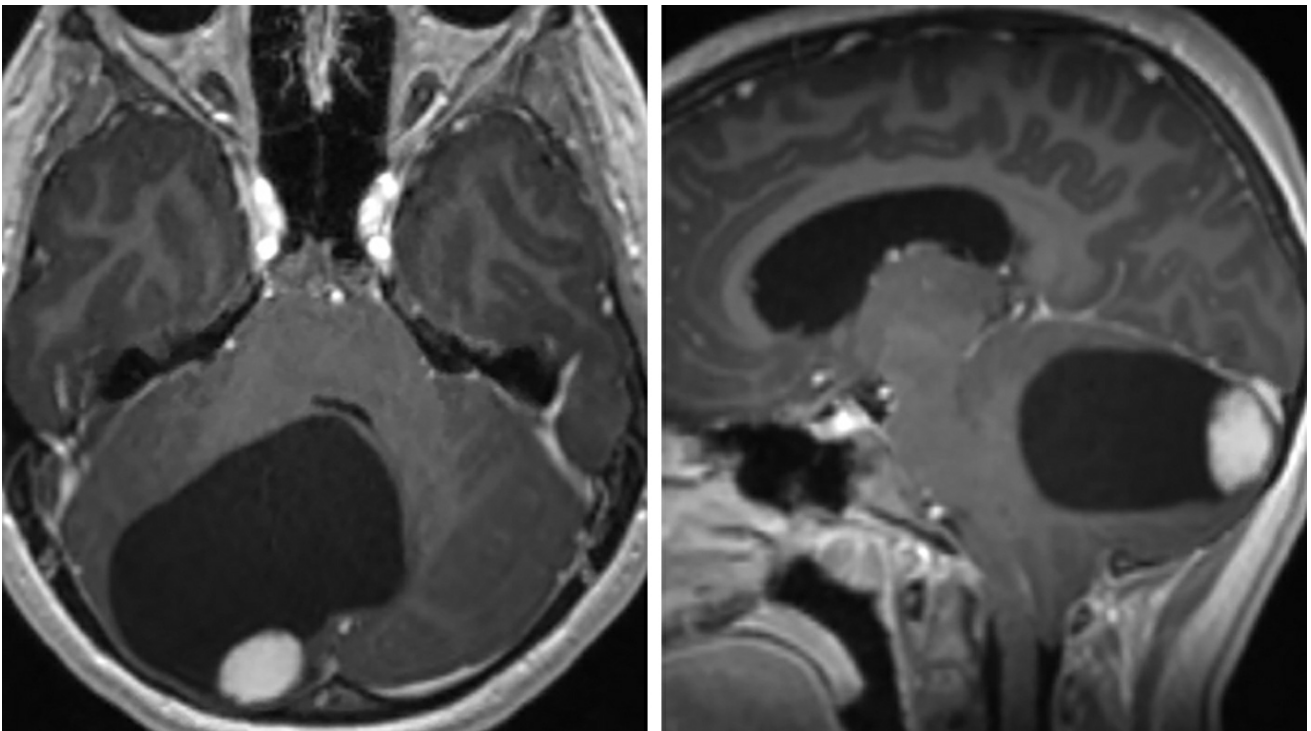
Axial (left) and sagittal (right) postcontrast T1-weighted images demonstrate a cystic lesion with a brightly enhancing mural nodule/mass. This appearance is very typical for juvenile PAs but must be distinguished from the similar-appearing [hemangioblastoma](#) when in the posterior fossa, particularly when in older children and young adults.
